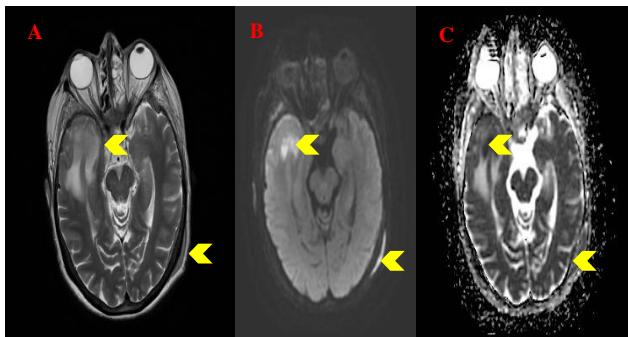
A) Axial T2WI, B) Axial diffusion C) ADC Map. Initial MRI-Right temporal brain lesion and Left parietal bone lesion also showing restricted diffusion.
